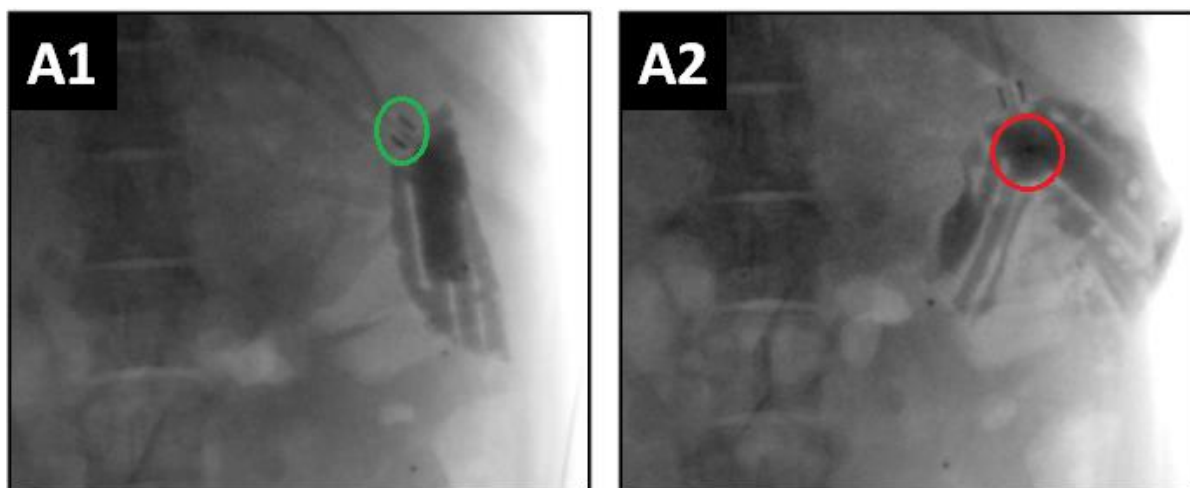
CT scan images of Shell A taken while filling with RGF1, where A1 was taken before A2. (A1) – Shows the filling port outlined in green, with minimal spread of gel through the shell; the darker area below the filling port indicates the gel is accumulating. (A2) – Shows the gel spreading minimally through the shell and the black spot outlined in red shows where the shell has burst.
